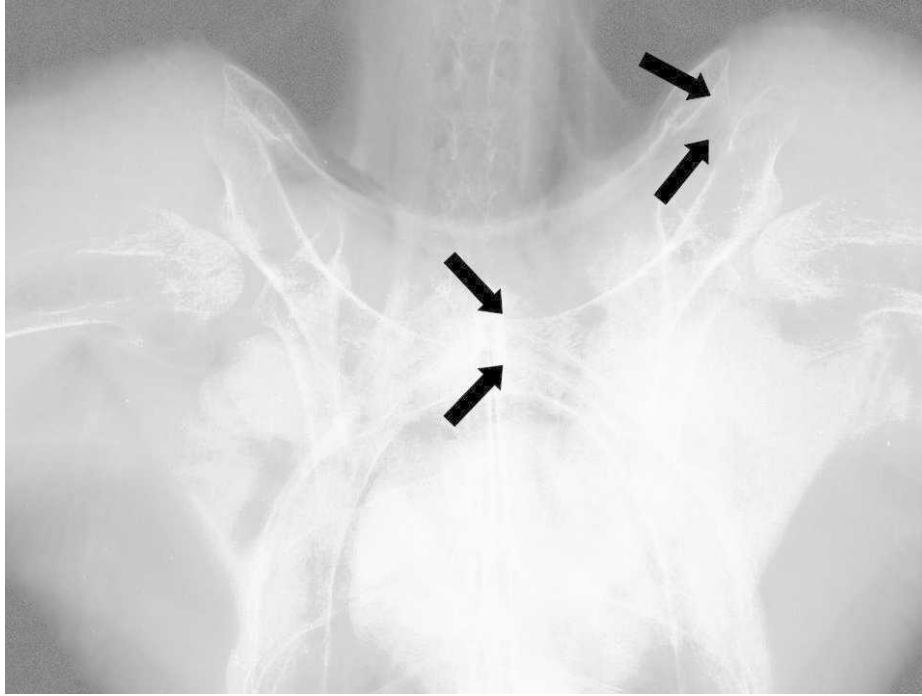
Ventrodorsal radiographic view of a bald eagle that presented for inability to fly. A luxation of the left coracoid is present (arrows).
